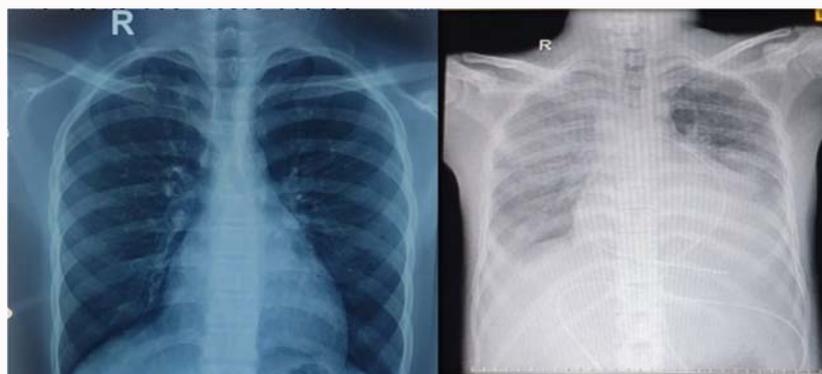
a) Chest X-ray (of the previous admission) showing straightening of the left heart border; b) Chest X-ray shows a pigtail catheter in the pericardial cavity and there is evidence of pulmonary oedema.
